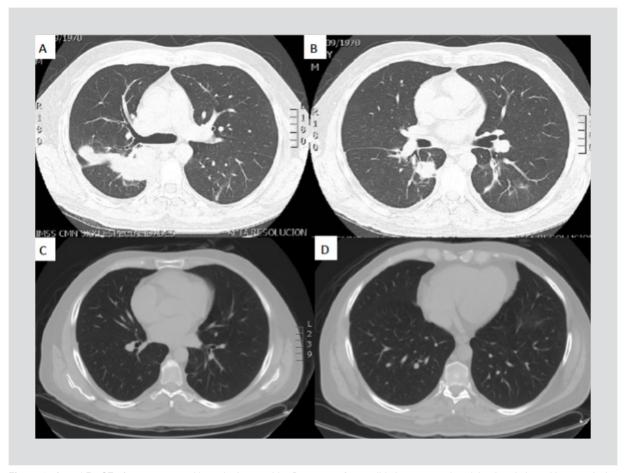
A and B: CT after treatment with cyclophospamide. Decrease of consolidation area and nodules in relation with tumor lesion located at right lung lower lobe upper segment of poorly-defined spiculated borders with 52 x 44 mm diameters and attenuation values of 47 UH; C and D: CT-scan at 4 years of treatment with pulmonary lesions resolution.
